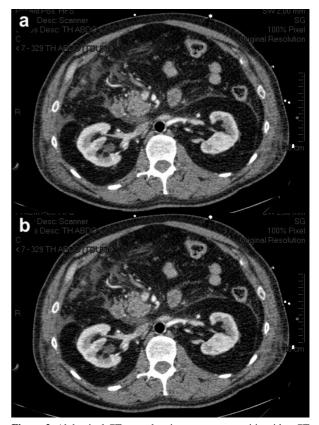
Abdominal CT scan showing acute pancreatitis with a CT severity index of four.
